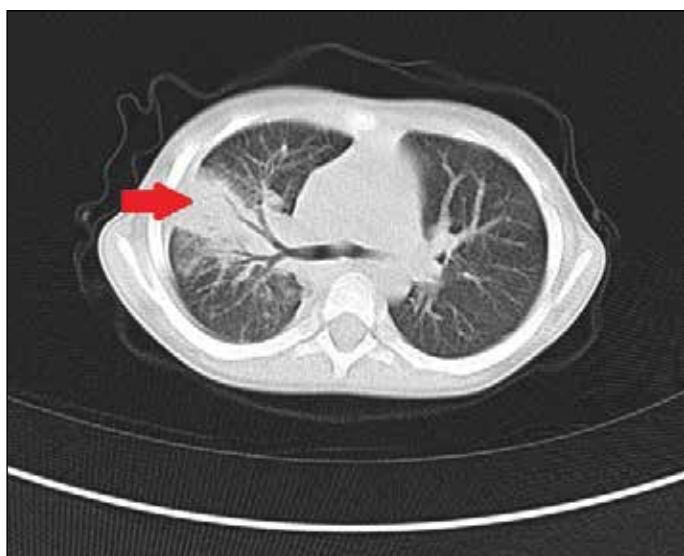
Thoracic CT scan of a patient with pneumonia shows air space consolidation of right upper lobe posterior segment.
